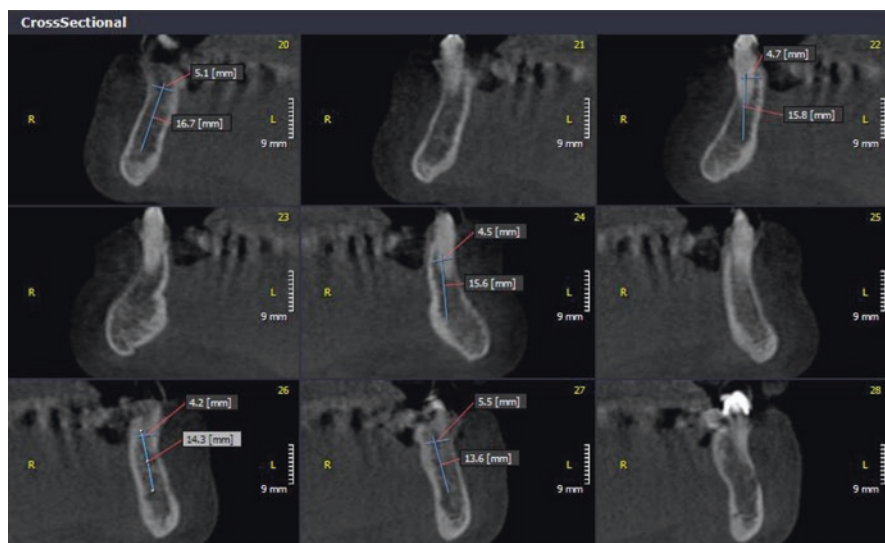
Cross-sectional view of a cone beam computed tomography (CBCT) scan
